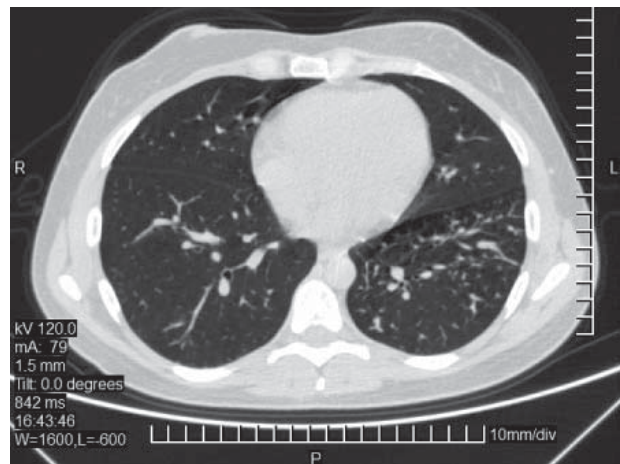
Chest CT scan of a patient with a HIV status after 2.5 years of treatment. The bullous changes in the parenchyma and focus of a specific tubercular process is noted
